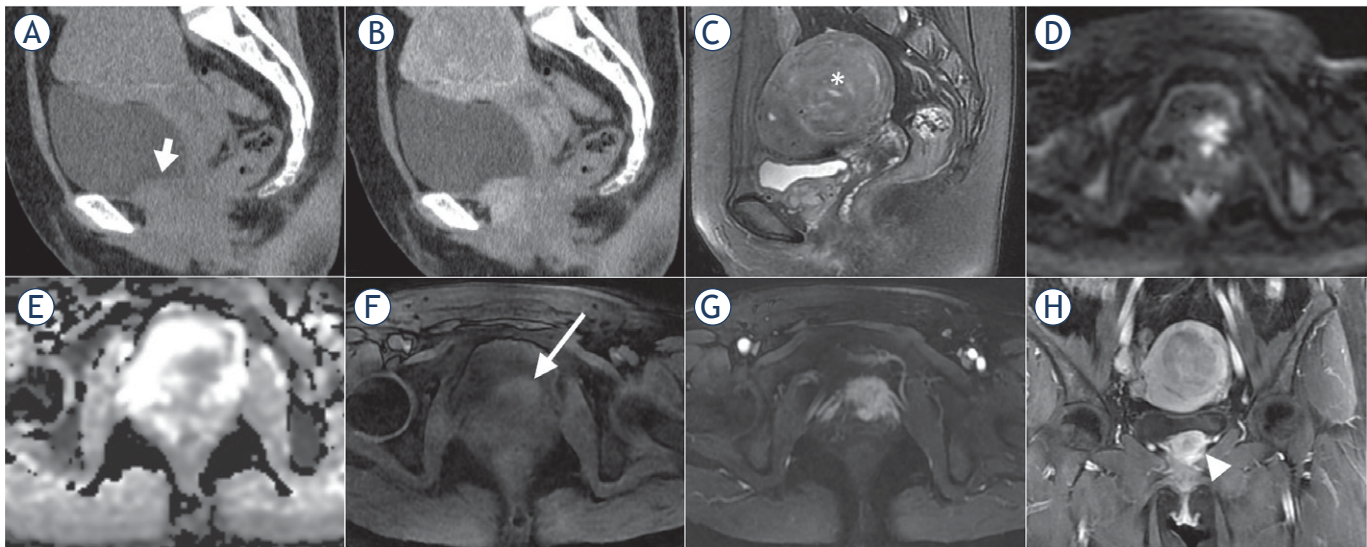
CT and MR images of a 47-year-old female with malignant bladder paraganglioma. The bladder tumour was located in the inferior bladder wall with an irregular shape and ill-defined margin, invading the adjacent tissues (short arrow). The tumour showed iso-density and moderate enhancement on sagittal pre- and post-contrast enhanced CT images (A, B), inhomogenous hyperintensity on sagittal T2-weighted images (T2WI) (C), hyperintensity on diffusion-weighted images (DWI) (D), hypointensity on apparent diffusion coefficient (ADC) maps (mean ADC value, $0.852 \times 10^{-3} \text{ mm}^2/\text{s}$) (E), inhomogenous slight hyperintensity compared to the *gluteus maximus* on T1-weighted images (T1WI) (long arrow) (F), heterogenous marked enhancement on arterial phase (G) and coronal contrast-enhanced images (arrowhead) (H). In addition, a uterine fibroid on the posterior wall of the uterus was also found (asterisk on sagittal T2WI).
